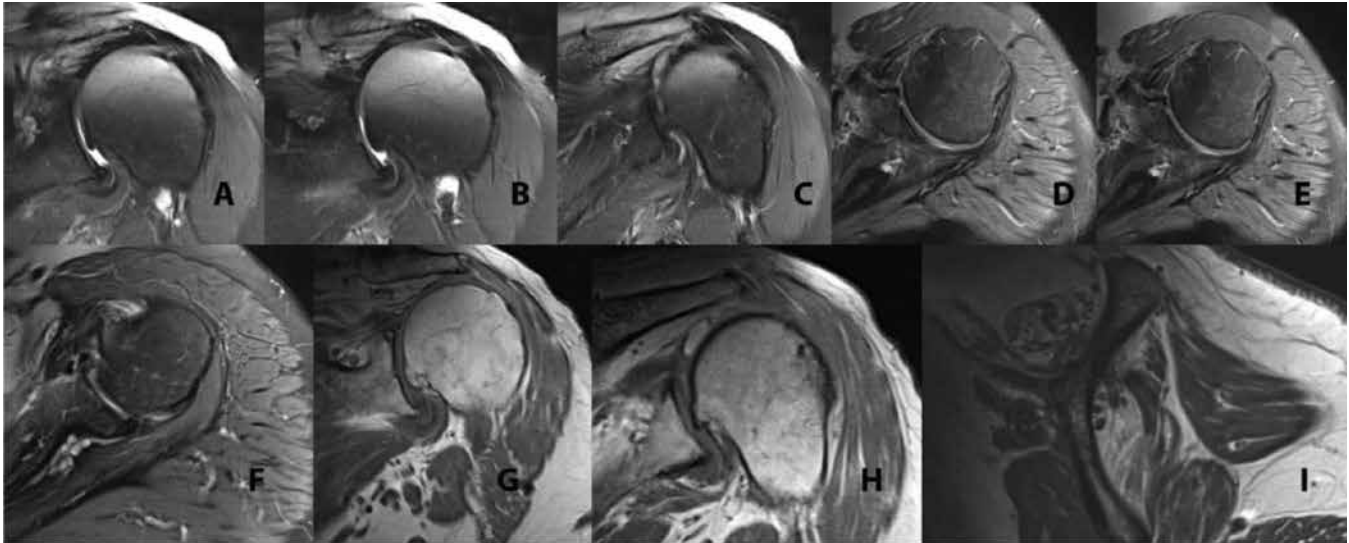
An MRI of the left shoulder. (A–C) A T2 coronal series demonstrating complete tearing of the supraspinatus tendon with medial retraction to the glenoid. (D–F) A T2 axial series demonstrating partial tearing and medial dislocation of the biceps tendon. (G–H) A T1 coronal series demonstrating good deltoid bulk without atrophy. (I) A T1 sagittal image demonstrating marked fatty atrophy of the supraspinatus and infraspinatus muscles.
